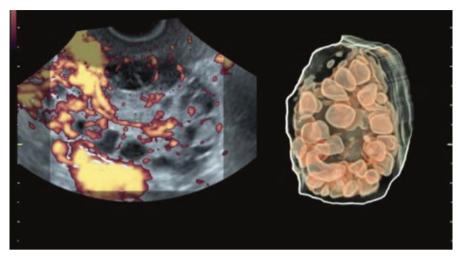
Antral follicles seen on 3D ultrasound volume of the ovary rendered on inversion mode
